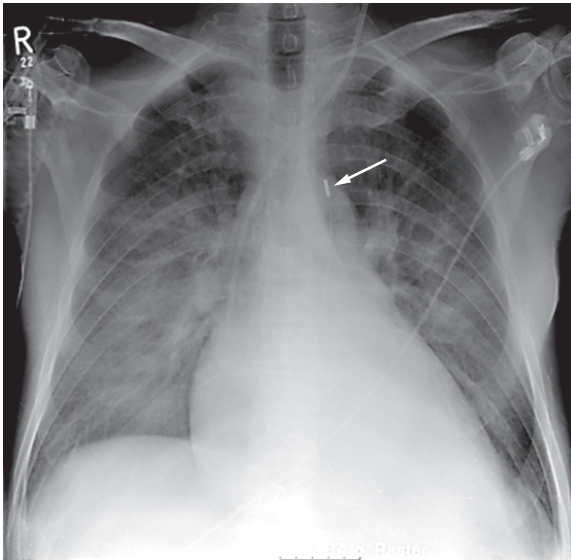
Thoracic X-ray for monitoring catheter placement. Thoracic image in the supine position for a patient with left heart failure and pulmonary edema. The image shows a central venous access placed superior to the left jugular vein in the upper hollow vein, and an intra-aortic balloon pump in the descending aorta (arrow).
